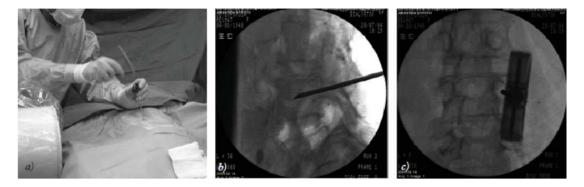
Vertebroplasty: (a) insertion of the needle into the vertebral body, (b) X-ray view in the lateral projection, (c) X-ray preview in the AP projection [15]
